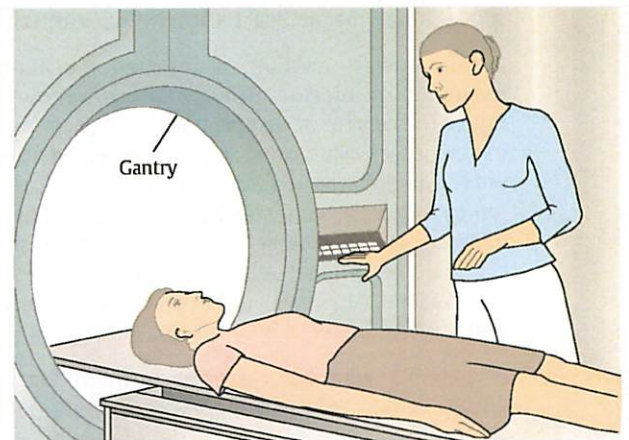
Possible positioning for computed tomography
